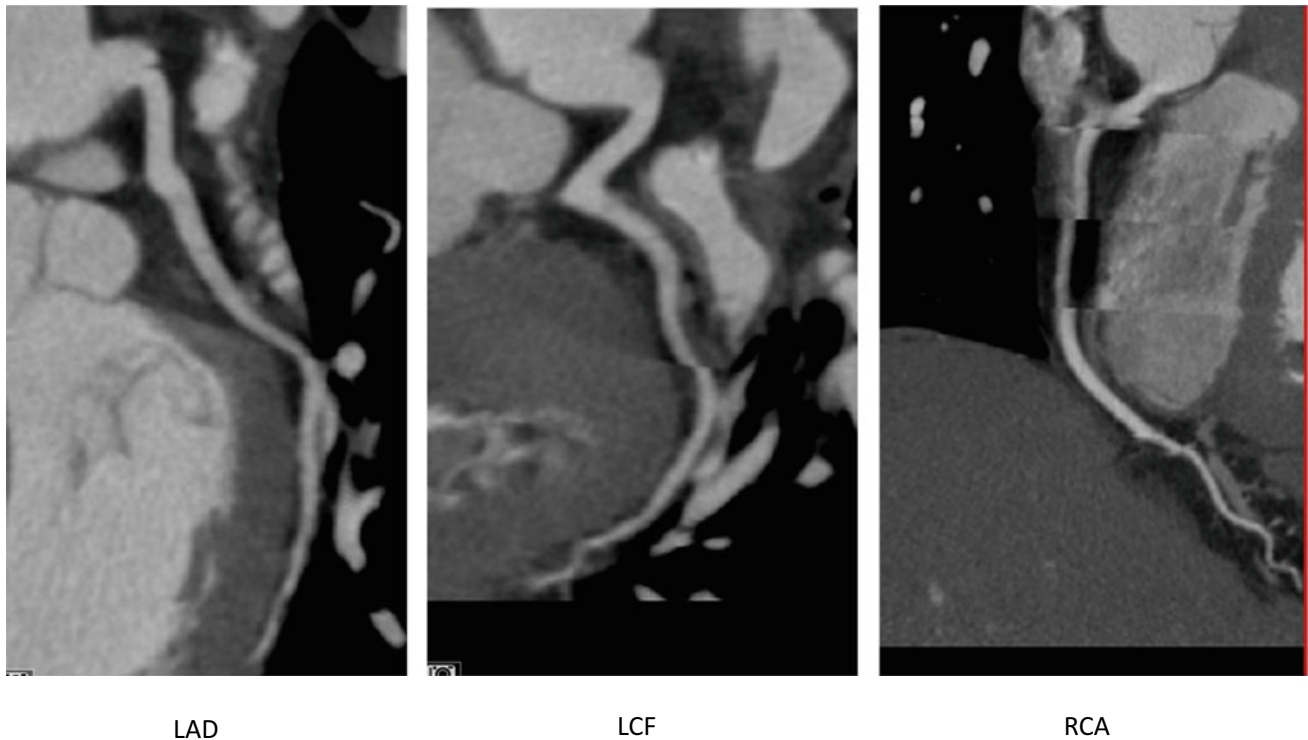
CT coronary angiogram revealing no significant obstructive coronary artery disease. The possibility of coronary artery disease should be entertained in every cancer patient that presents with ventricular dysfunction
